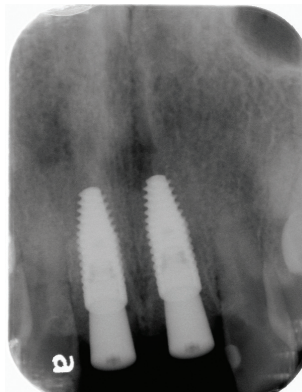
Periapical x-ray was taken after implants were placed
